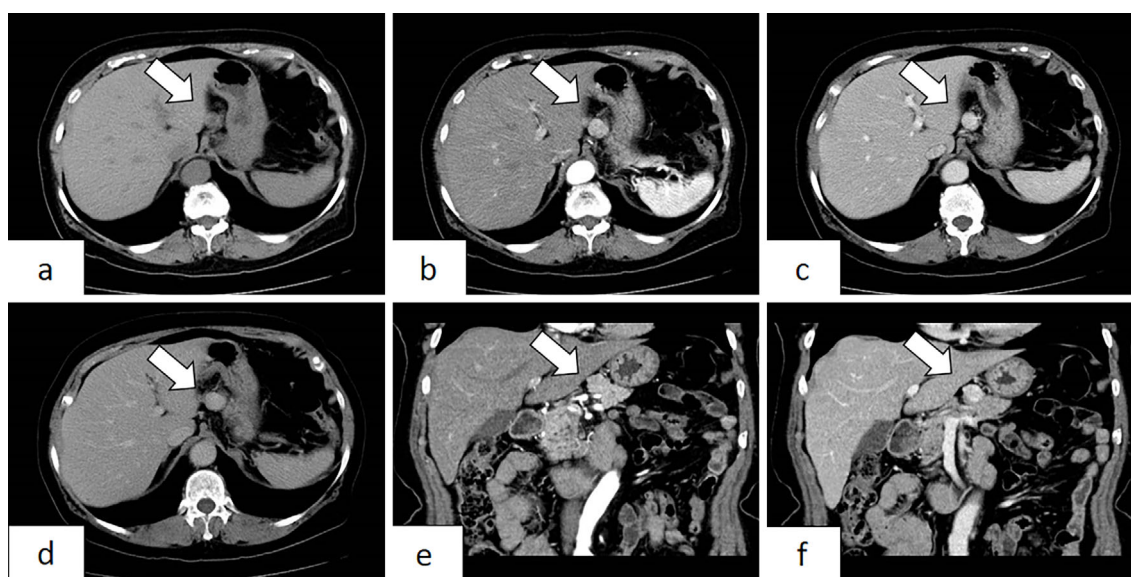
Abdominal contrast-enhanced computed tomography findings. In the pancreatic body, a round mass with a high density in the delayed phase extending outside the pancreas was found (arrow). In the early phase, the contrast effects were approximately the same as in the pancreatic parenchyma, whereas in the venous phase, they were greater, indicating delayed enhancement. (a) Plain phase, (b) early phase, (c) venous phase, (d) delayed phase, (e) early phase, coronal section, (f) delayed phase, coronal section.
